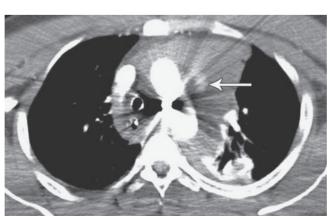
Ruptured aorta (a) Angiogram showing a rupture of the arch of the aorta. (b) CT scan showing the haematoma around the rupture. Complete transection or rupture is immediately fatal, but the haematoma can be contained by the adventitial layer of the aortic wall, enabling the patient to survive to reach hospital.
